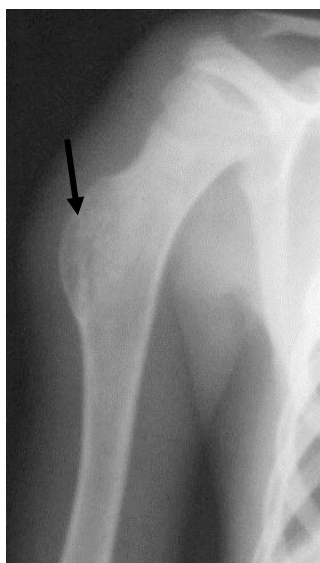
The radiograph of the humeral bone in a direct projection. The mass in the top third of diaphysis of the humeral bone with wide basis connected with the bone is detected (arrow). There are no periosteal reactions, contours are distinct. Radiological symptoms of osteoma are detected (a benign tumour of a bone)
